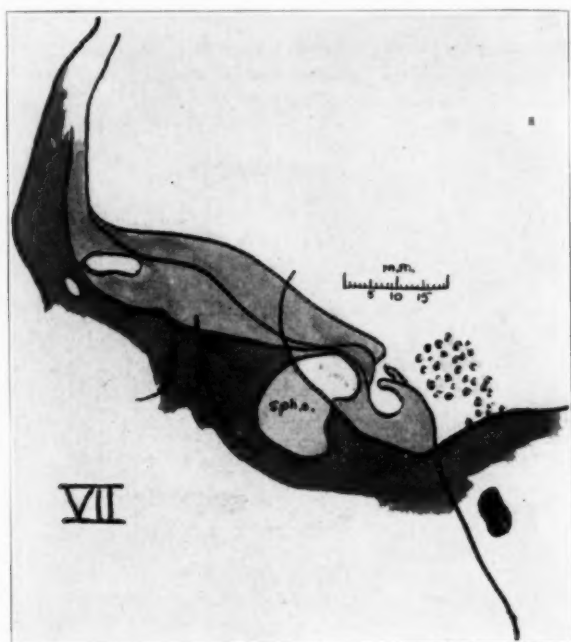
(case 7).—A sketch of the roentgenogram (fig. 21), drawn to scale.
